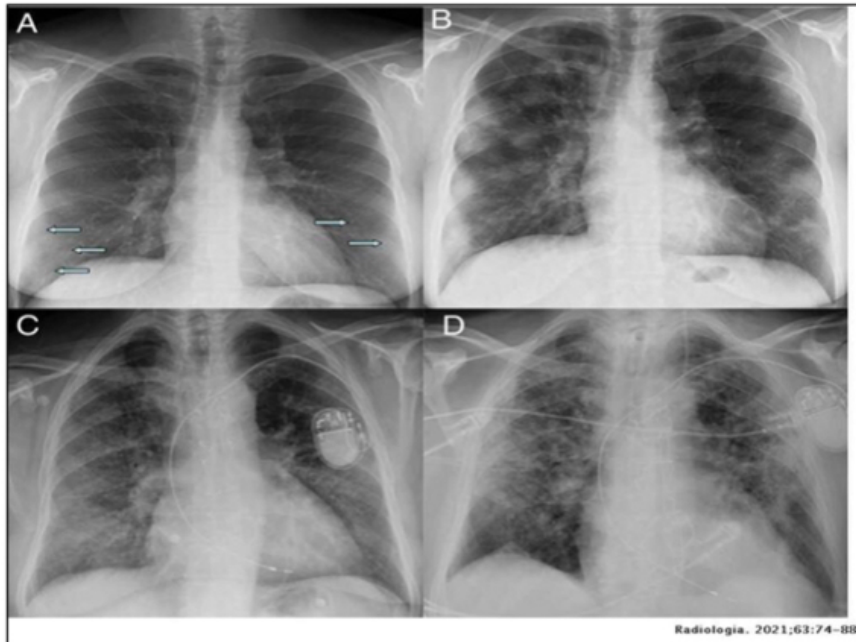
Lung X-ray of COVID-19 patient
